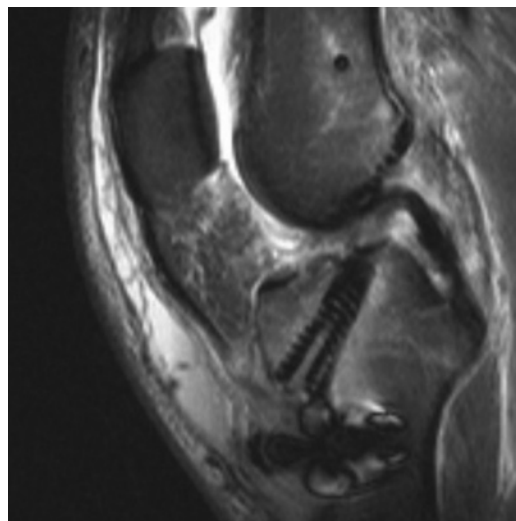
Infected infrapatellar bursitis. Sagittal T2-weighted fat-suppressed fast spin-echo MR image shows a subcutaneous fluid collection overlying the opening of the anterior tibial tunnel. Reactive marrow edema is seen in the proximal tibia. No evidence of osteomyelitis was found at intraoperative biopsy.
